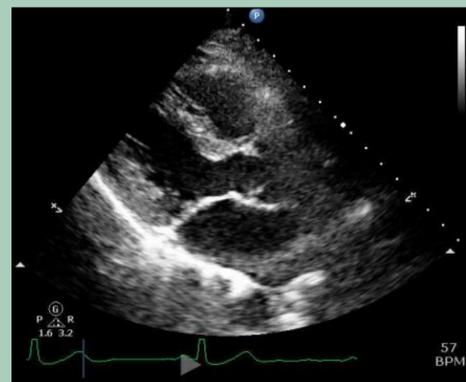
TTE parasternal long axis and apical 4 chamber views showing normal heart function with aortic valve sclerosis but no stenosis.
